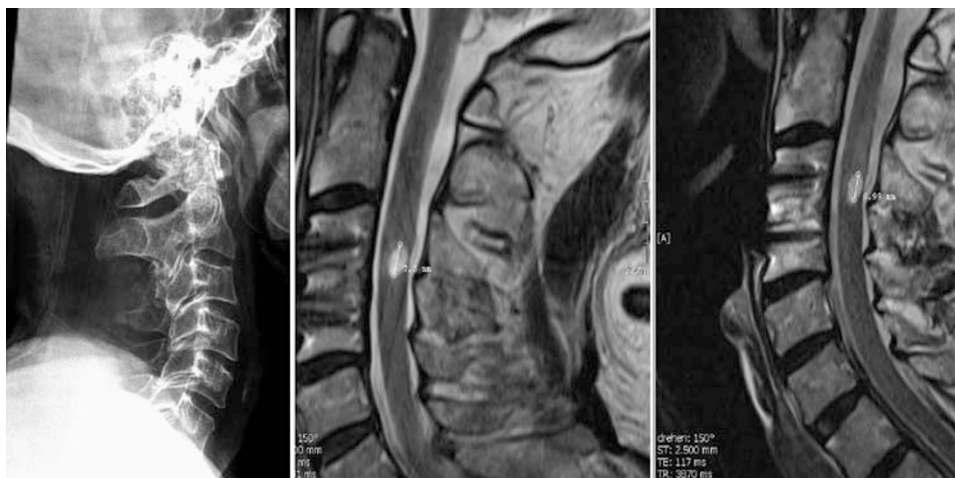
Initial cervical X-ray with minimal dislocation C3/C4 and follow-up MRIs of the cervical spinal cord 3 and 7 months after SCI. Sagittal T2-weighted SE images showing a post-traumatic cyst at level C3/C4.
